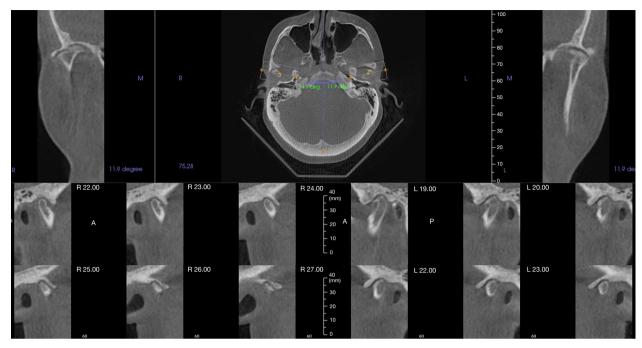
CT scan of the same patient as in Figure 4 showing significant flattening of the articular surfaces with osteophyte formation and decreased joint space. CT, computerized tomography.
